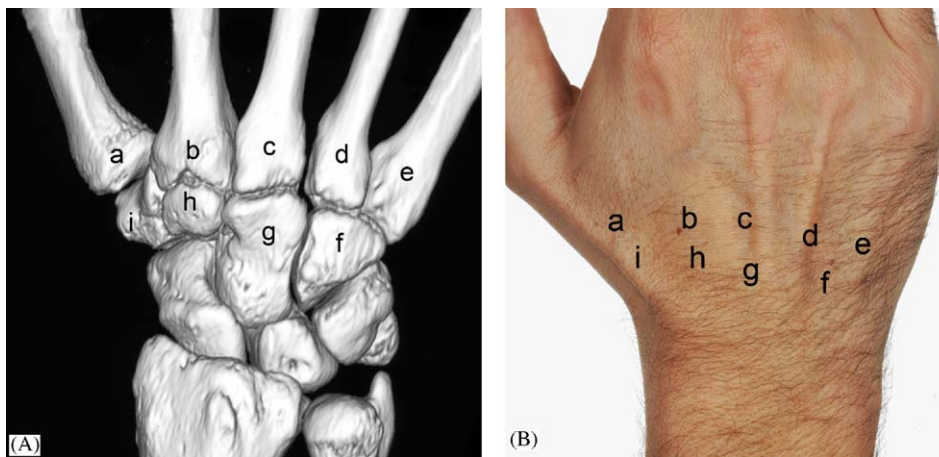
Dorsal view of the wrist and carpus as 3D CT reconstruction (A) and clinical photograph (B), following the metacarpals to their bases towards the carpometacarpal joints. Landmarks in both the figures are—(a) thumb (1st) metacarpal, (b) index finger (2nd) metacarpal, (c) middle finger (3rd) metacarpal, (d) ring finger (4th) metacarpal, (e) little finger (5th) metacarpal, (f) hamate, (g) capitate, (h) trapezoid, (i) trapezium.
